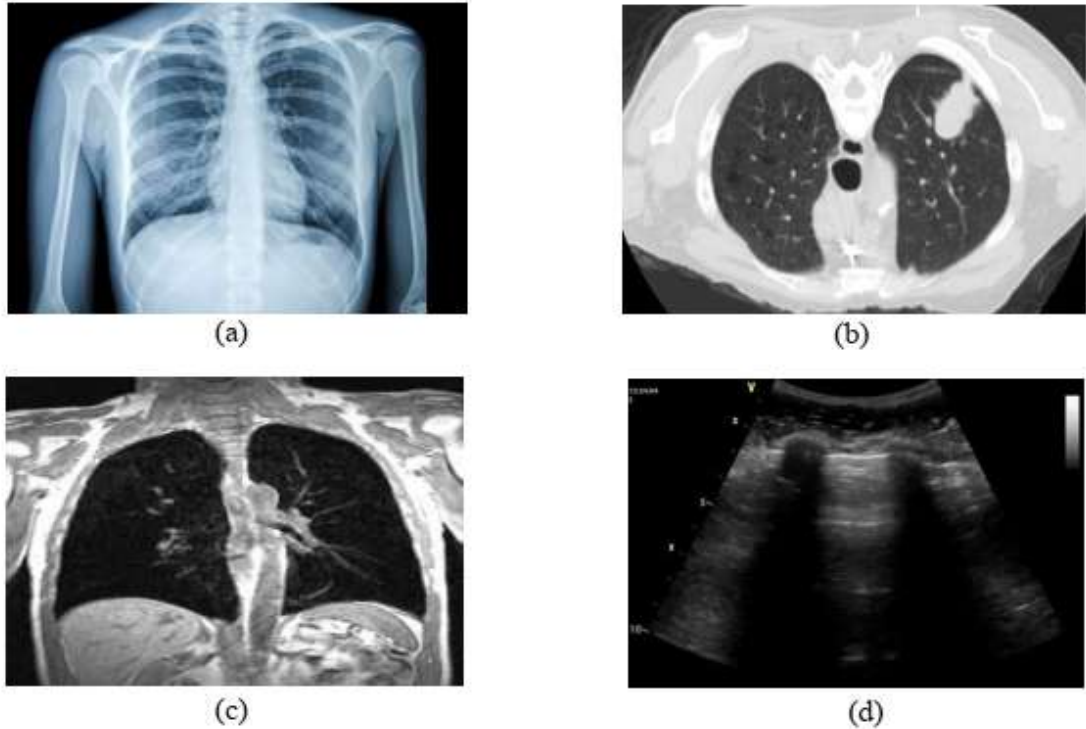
Different medical imaging for lung visualization (a) X-ray (b) CT Scan (c) MRI (d) Ultrasound
